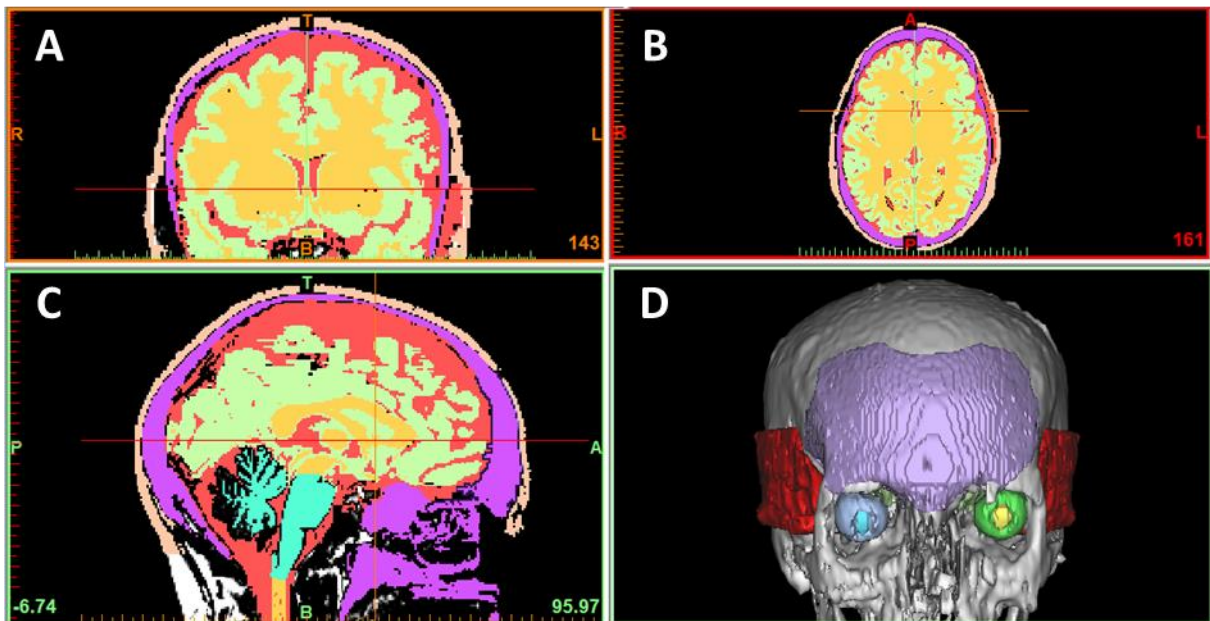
MRI segmentation and 3D reconstruction of temporal and frontal craniofacial muscles. A) Frontal, B) transverse, and C) sagittal plane cranial MRI slices. D) 3D reconstruction showing frontal (purple) and temporal (red) craniofacial muscles.
